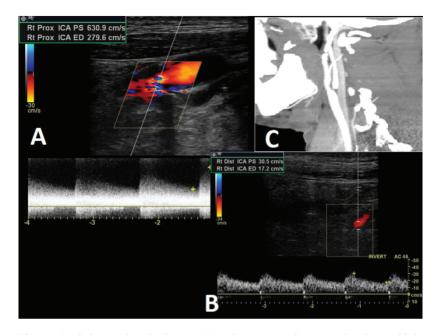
Color and pulsed-wave Doppler across the stenosis shows high PSV/EDV (630.9/279.6cm/s) (A). Distal ICA Doppler shows blunting of waveforms (30.5/17.2 cm/s) suggesting severity of stenosis (B). CT Angiogram correlates of the ICA stenosis (C).
